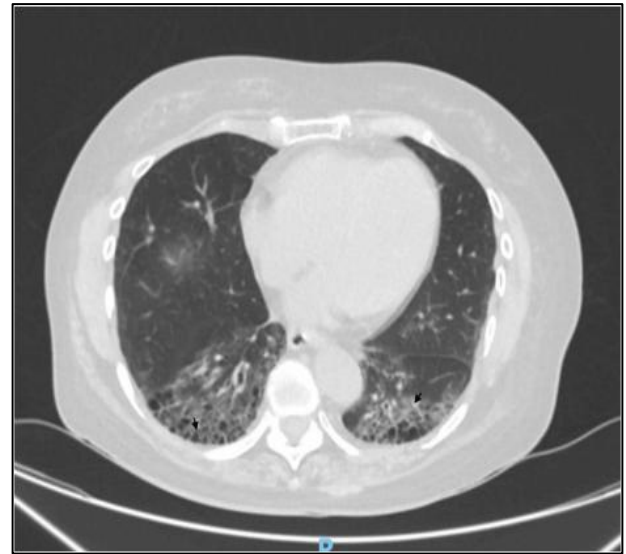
Computed tomography (CT) Chest showed peripheral reticular opacities, traction bronchiectasis and exuberant honeycombing within the lung bases (arrows).
